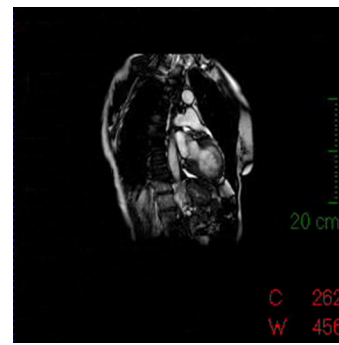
Cardiac magnetic resonance image showing left ventricular apical akinesia and basal hyperkinesis at end-systole without signs of ischemic lesions.
